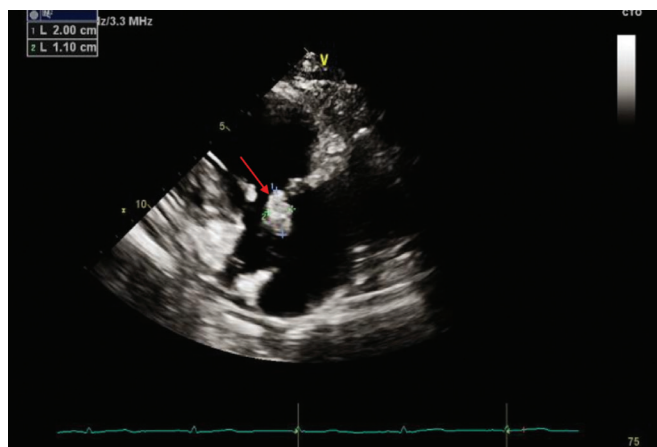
Transthoracic echocardiogram, showing a tricuspid valve vegetation (red arrow). There is a second vegetation not shown in this view. The vegetations prolapse across the tricuspid valve annulus. There is moderate to severe tricuspid regurgitation, a small pericardial effusion (8 mm) and a dilated inferior vena cava (not shown).
